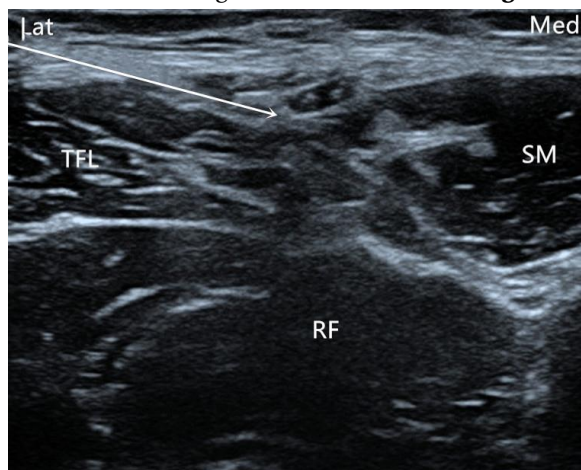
Ultrasound image of LFCNB. TFL: tensor fasciae latae muscle; SM: sartorius muscle; RF: rectus femoris muscle; Lat: lateral; Med: medial. The red arrow points to the injection location.
